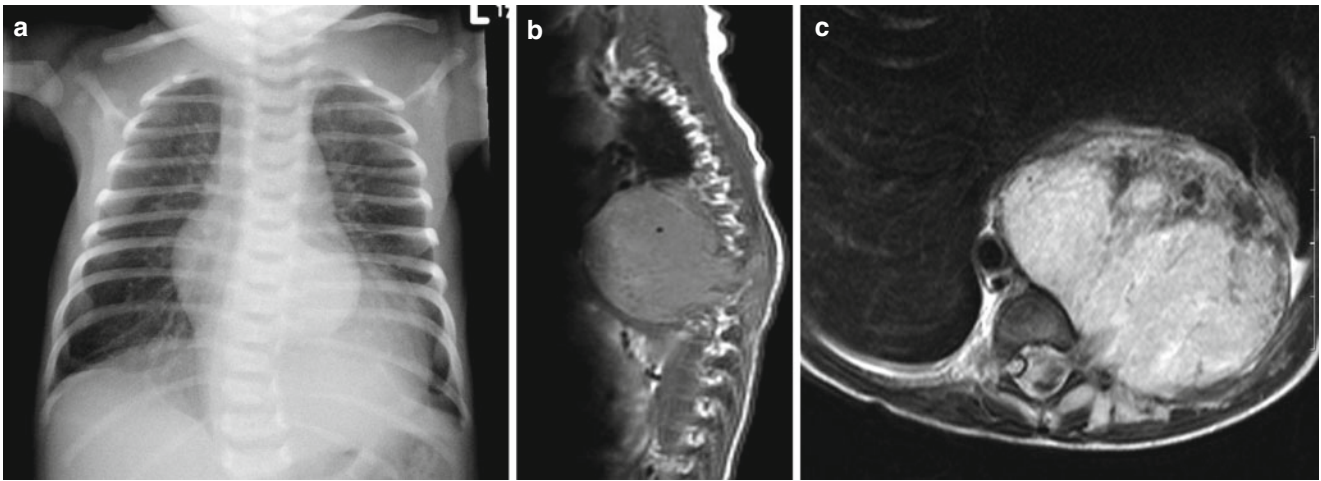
Thoracic neuroblastoma with intraspinal extension. (a) Chest radiograph showing a large low left sided thoracic mass with splaying of the left sided ribs and causing a thoracic scoliosis. (b) Sagittal MR showing tumor extending through the thoracic intervertebral foramina at several levels. (c) Axial MR after gadolinium showing the left sided tumor extending into the spinal canal and markedly compressing and displacing the spinal cord to the far right side of the spinal canal
